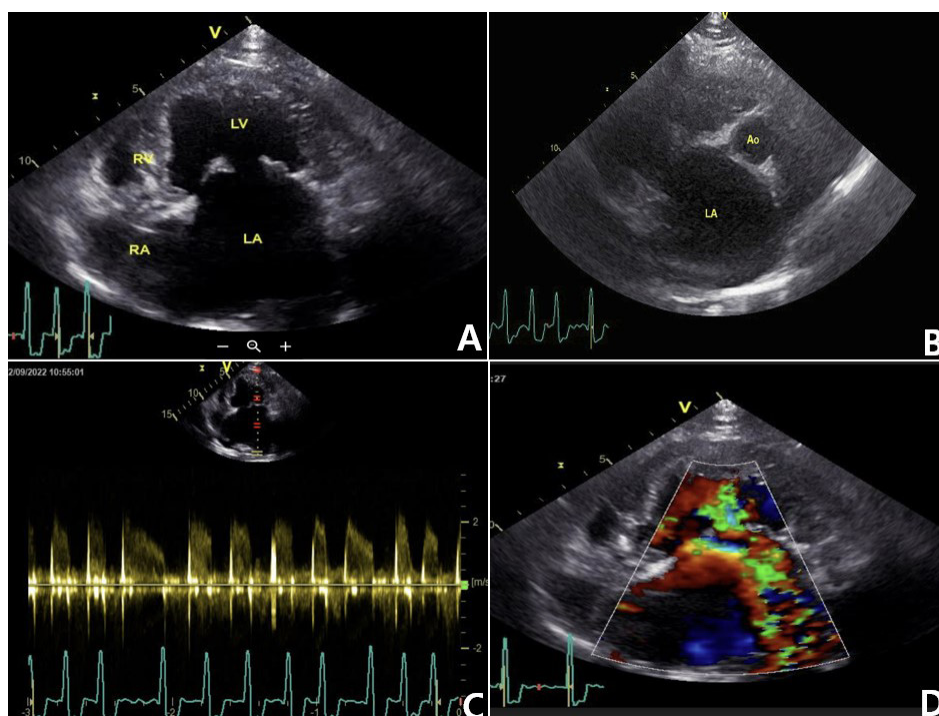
(A) Left apical view showing left atrial enlargement and mitral valve leaflets thickening and diastolic doming. (B) Right parasternal four-chamber long axis view showing severe left atrial enlargement (LA/Ao=2.66). (C) Pulsed-wave Doppler pattern with high velocity fused E and A wave mitral inflow. (D) Severe mitral regurgitant area and a turbulent inflow jet within the left ventricle.
